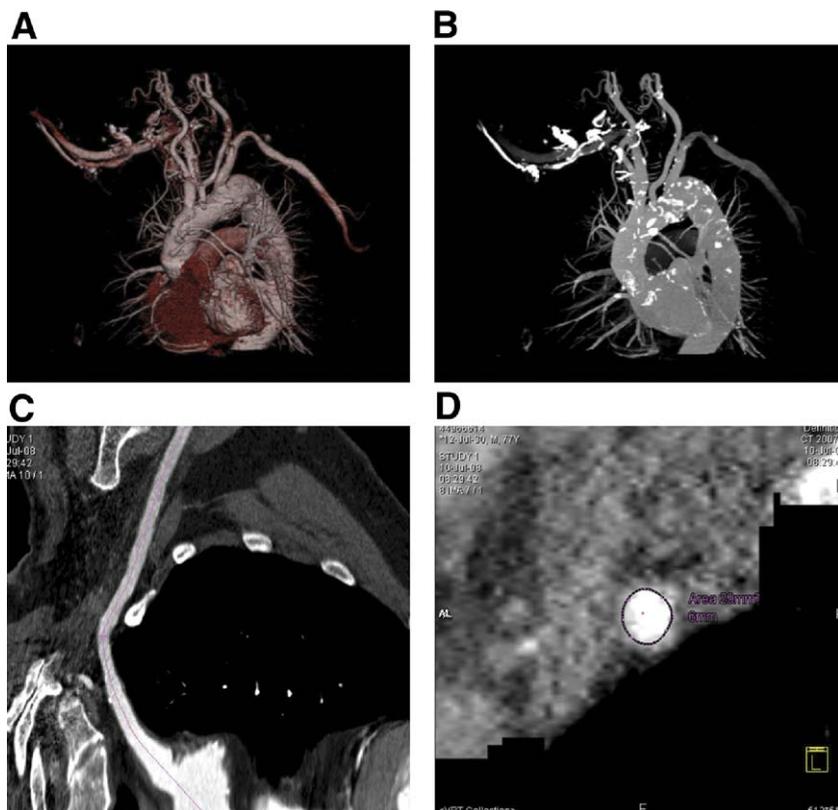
Computed Tomographic Angiography of Left Subclavian Artery
